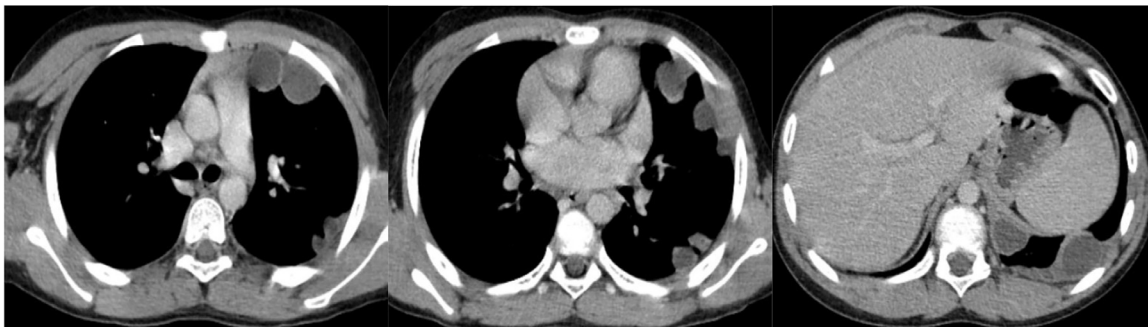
Axial chest CT showing uniloculated left subpleural cystic formations.
